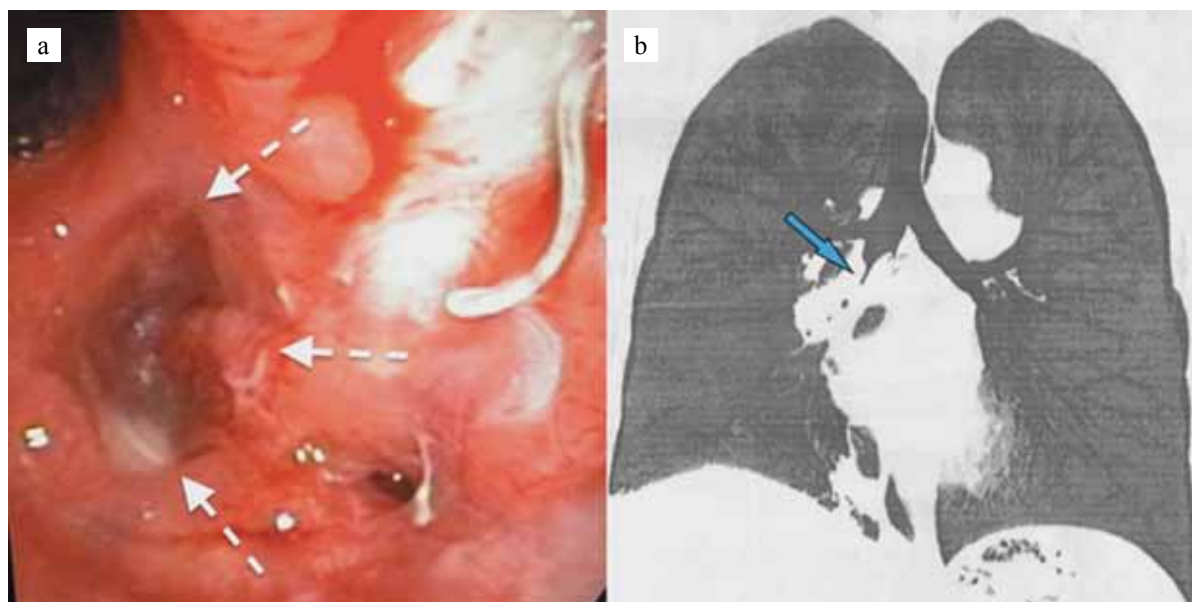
Cicatricial occlusion of the bronchus intermedius: a – endoscopic picture of the occlusion of the bronchus intermedius (indicated by arrows); b – CT signs of occlusion (indicated by an arrow)
